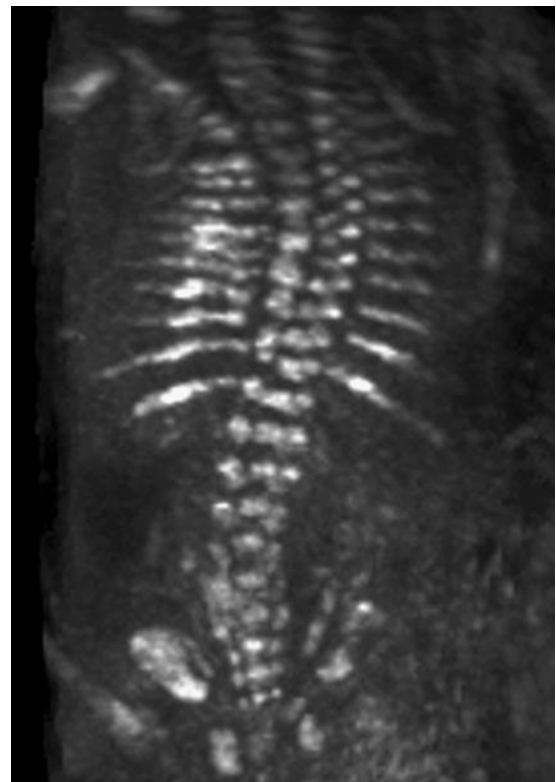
Three-dimensional ultrasound image of the fetal spine showing scoliosis.
